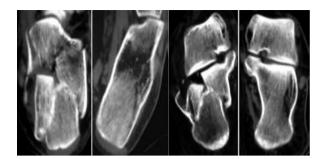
Coronal (A) and transverse (B) computed tomographic scans.
